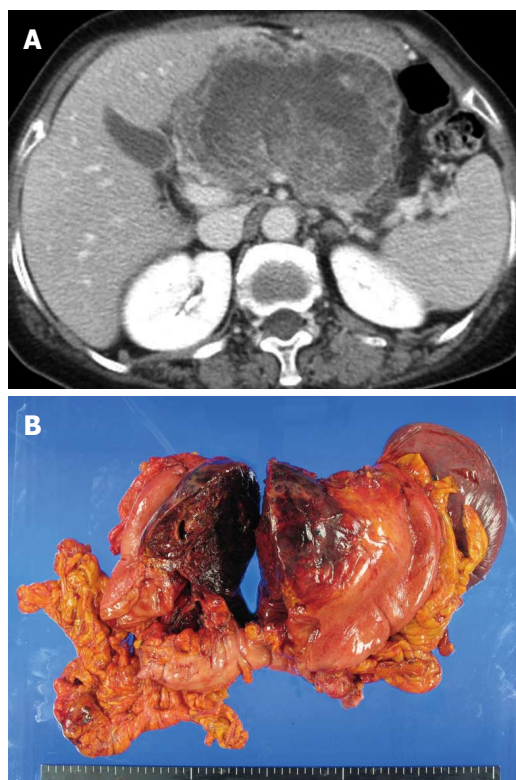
Huge undifferentiated carcinoma with osteoclast-like giant cells. A: Computed tomography scans revealed the tumor occupying the lesser sac; B: Tumor arose from the pancreas body and invaded directly the stomach wall and transverse mesocolon.
